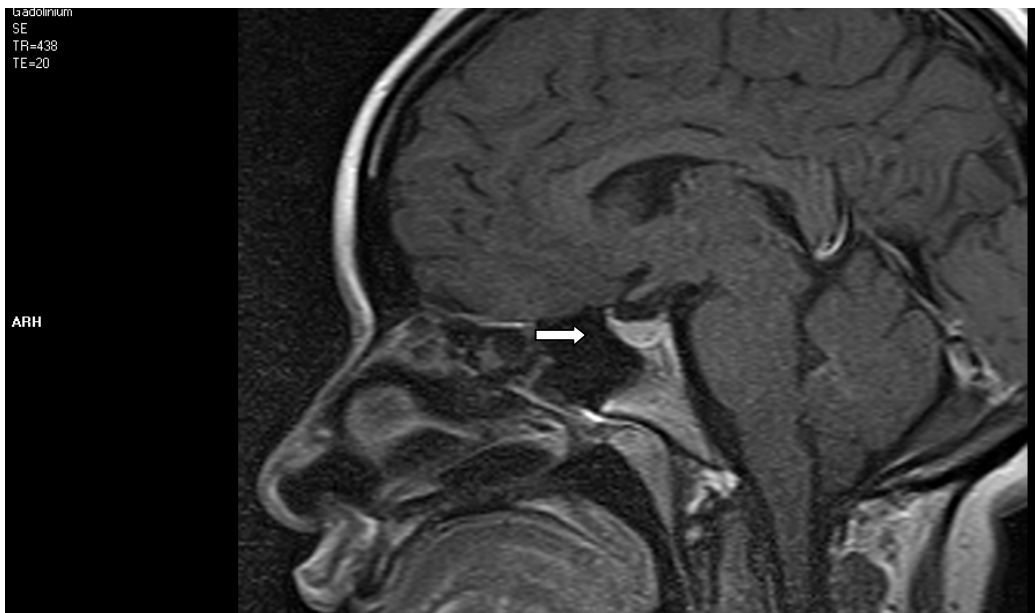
MRI Brain sagittal T1 WI with contrast showing Normal pituitary for 25 years old female
